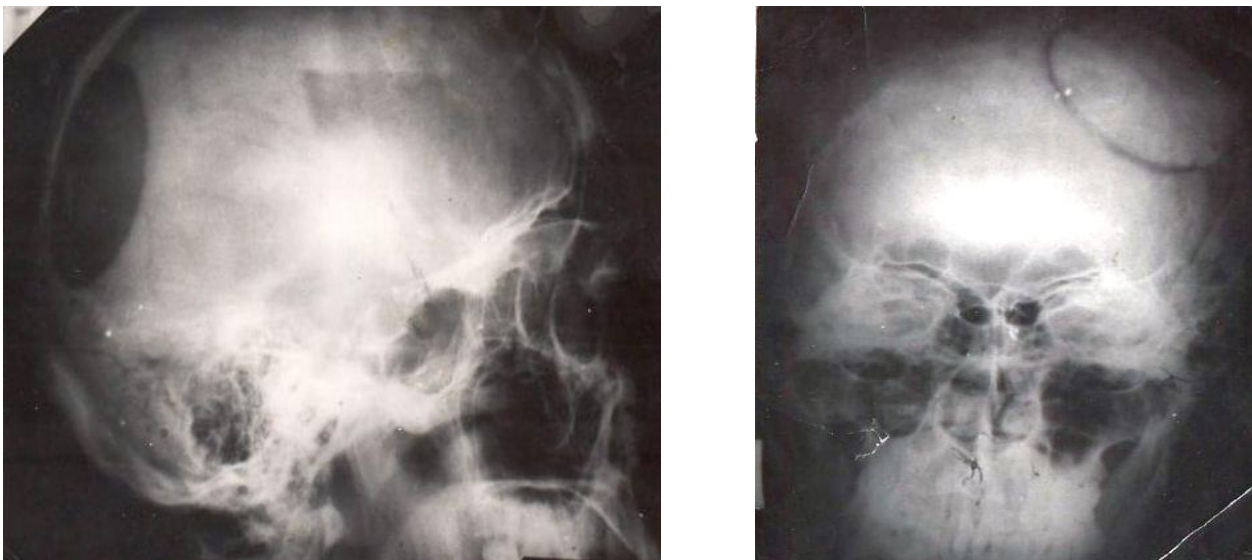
X-ray of a patient with a defect in the bones of the cranial vault (before and after surgery for defect repair).
